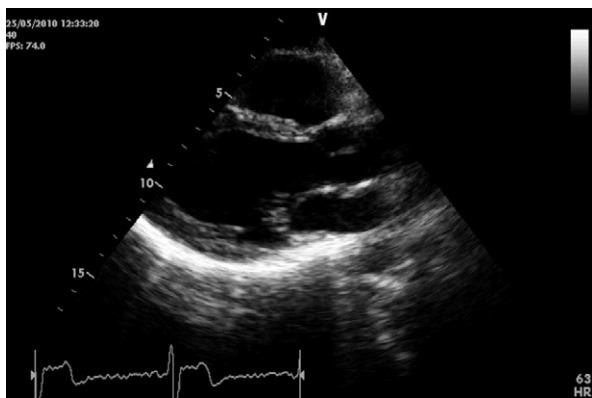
Transthoracic echocardiogram performed on follow-up evaluation reveals no pericardial effusion.
